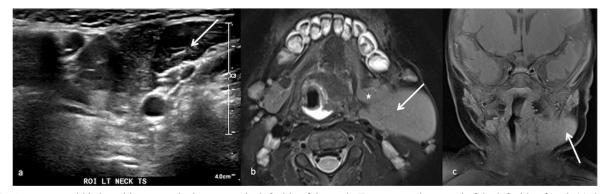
A one-year-old baby with an ectopic thymus on the left side of the neck. Transverse ultrasound of the left side of neck (a) demonstrates a soft tissue lesion (arrow) with parenchymal echogenicity resembling 'starry night' appearance indicating thymic tissues. Axial T2 (b) and coronal T1-weighted images (c) of the neck demonstrate mild hyperintense soft tissue lesion situated lateral to the left submandibular gland (star) compatible to an ectopic thymic tissue (arrows).
